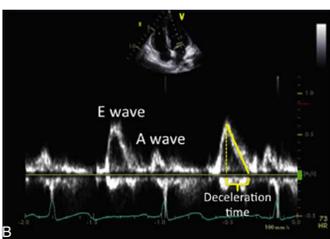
Mitral Doppler time velocity curve was analyzed for peak flow velocities at early (E) and late (A) diastole as well as their ratio (E/A). Deceleration time (DT) was calculated by measuring the time interval from the peak E-wave point at which the descending slope of the E-wave crosses the zero velocity baseline. Isovolumic relaxation time was measured from the time between the closure of the aortic valve to the opening of the mitral valve.
